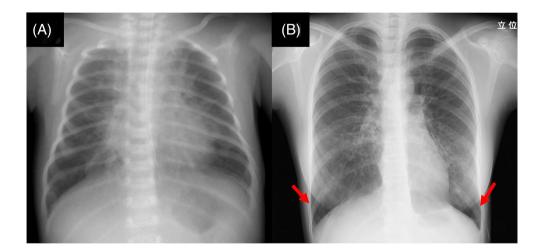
Findings from chest radiography. (A) Chest radiography at 0 years old with respiratory syncytial virus infection. No congenital abnormalities are apparent. (B) Chest radiography showed thickening of the bronchial walls and permeability in bilateral lower lung fields at the initial visit (arrow).
